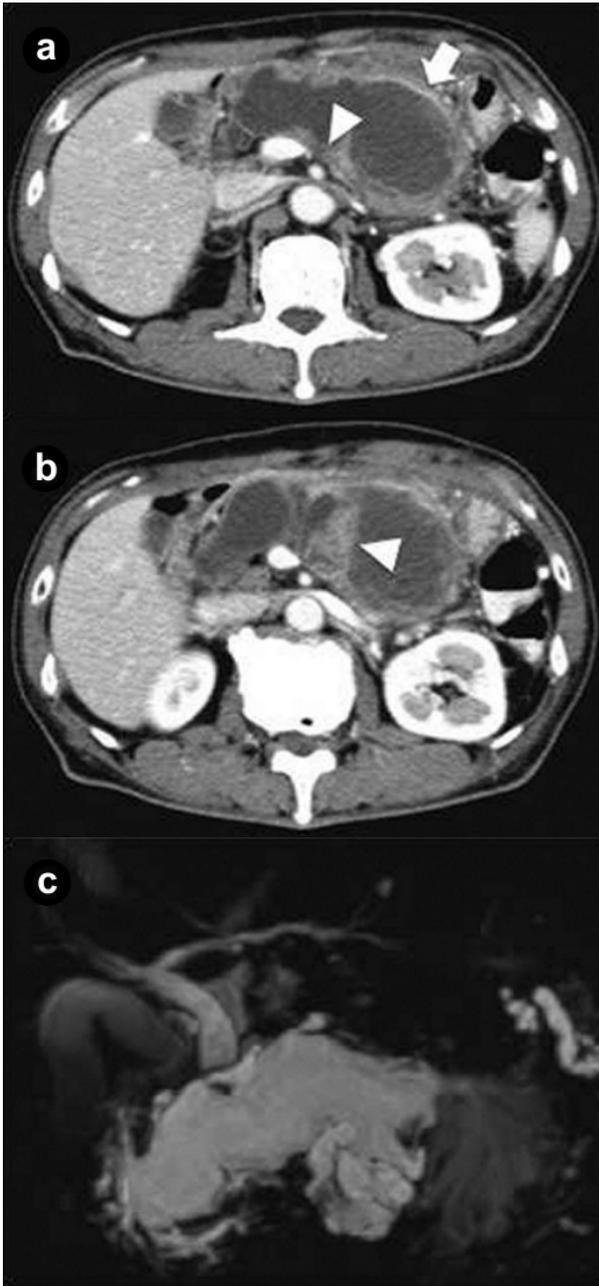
a. Computed tomography (CT) showed a markedly dilated main pancreatic duct (45 mm, arrow) and splenic vein obstruction (arrowhead). b. CT showed a papillary tumor (20 mm in diameter) protruding into the main pancreatic duct of the distal pancreas (arrowhead). c. Magnetic resonance cholangiopancreatography (MRCP) showed a markedly dilated main pancreatic duct.
